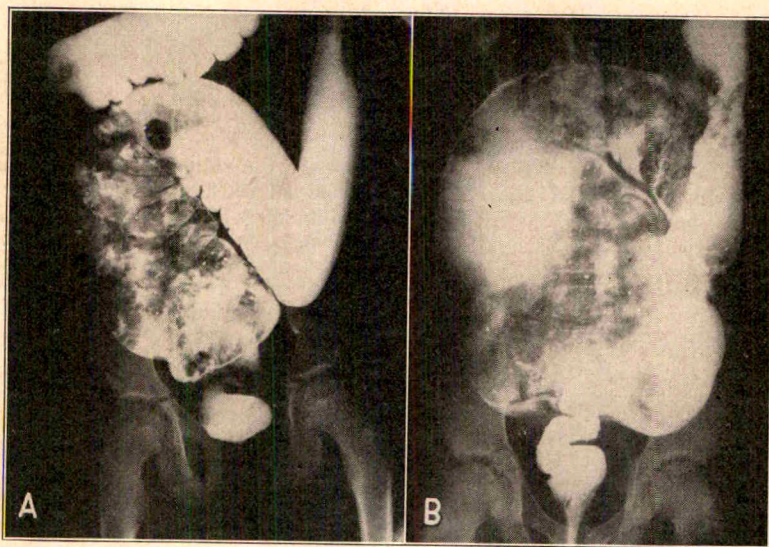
(case 22).—A, roentgenogram showing the normal rectum and the normal lower portion of sigmoid flexure present below the enlarged and impacted upper sigmoid colon in an 11 year old boy. Evacuation of the colon was difficult. B, roentgenogram of the same patient showing enormous distention and impaction of the descending colon and the upper portion of the sigmoid colon. Medical management had been employed seven months. The normal rectum and lower sigmoid are again demonstrated.
